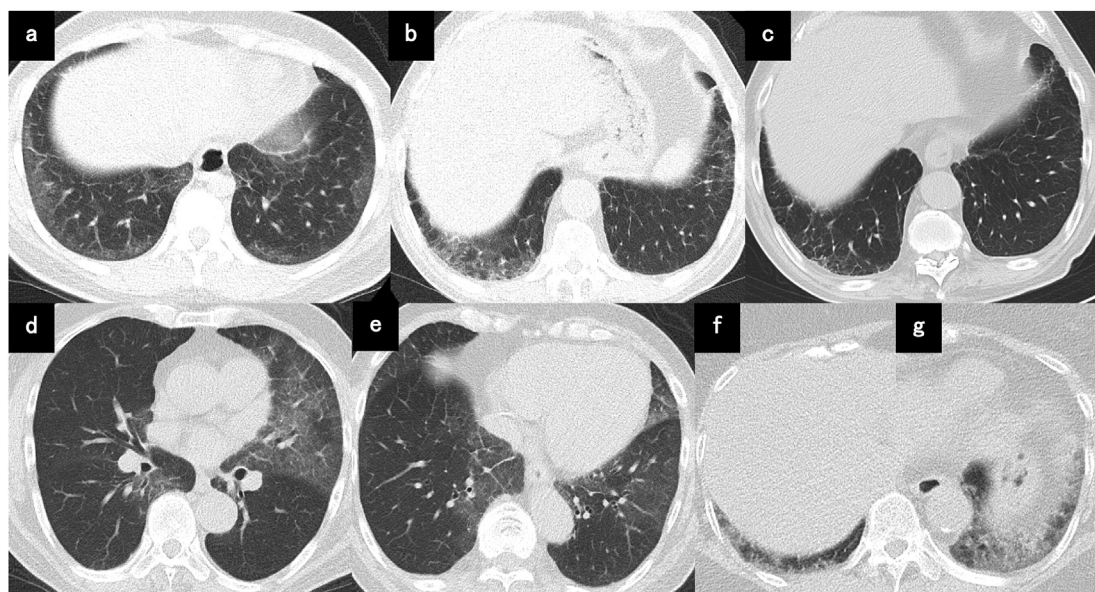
Computed tomography (CT) images depicting different lung diseases that mimic COVID-19 pneumonia. (a) Non-specific interstitial pneumonia classified as “typical appearance” of COVID-19 pneumonia in a 31-year old woman with systemic scleroderma. The axial chest CT image shows an area of a ground-glass opacity (GGO) with peripheral distribution in the posterior basal segment of the bilateral lower lobe. (b) Exacerbation of interstitial pneumonia classified as the “typical appearance” of COVID-19 pneumonia in an 84-year old man before transurethral lithotripsy. (c) Axial chest CT image showing new lesions with areas of GGO (arrow) with peripheral distribution in the posterior basal segment of the bilateral lower lobe, which were not detected 6 months earlier. (d, e) Drug-induced pneumonia classified as “typical appearance” of COVID-19 pneumonia in a 70-year old man before percutaneous coronary intervention. The axial chest CT image shows an area of small GGO with peripheral distribution in the middle and bilateral lower lobe. (f, g) Lung collapse classified as “typical appearance” of COVID-19 pneumonia in a 74-year old woman before total knee arthroplasty. The axial chest CT image shows an area of GGO with peripheral distribution in the bilateral lower lobe.
